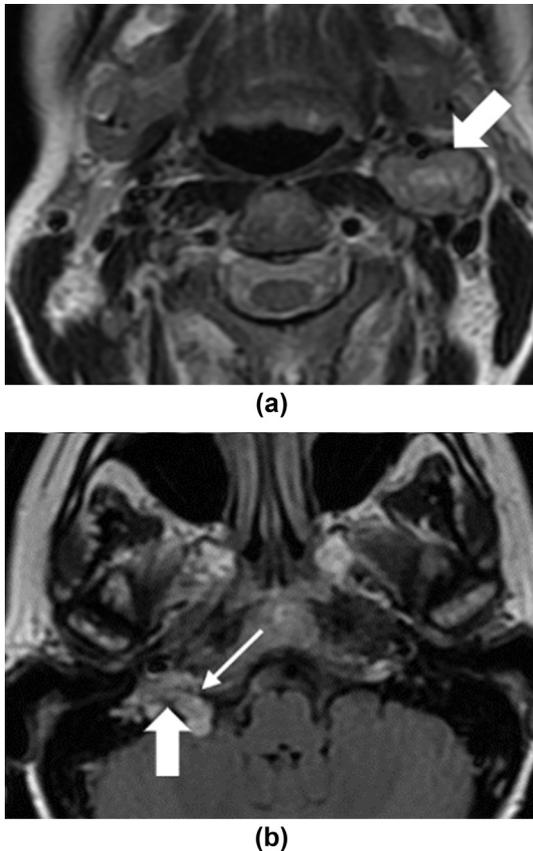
(a) Axial T2 MRI image of 46-year-old woman with paraganglioma syndrome 1 and known left carotid paraganglioma. (b) Follow-up axial IR MRI image now demonstrating a right jugulotympanic paraganglioma. Note the heterogeneous T2 hyperintensity and expansion of the jugular foramen (thin arrow).
